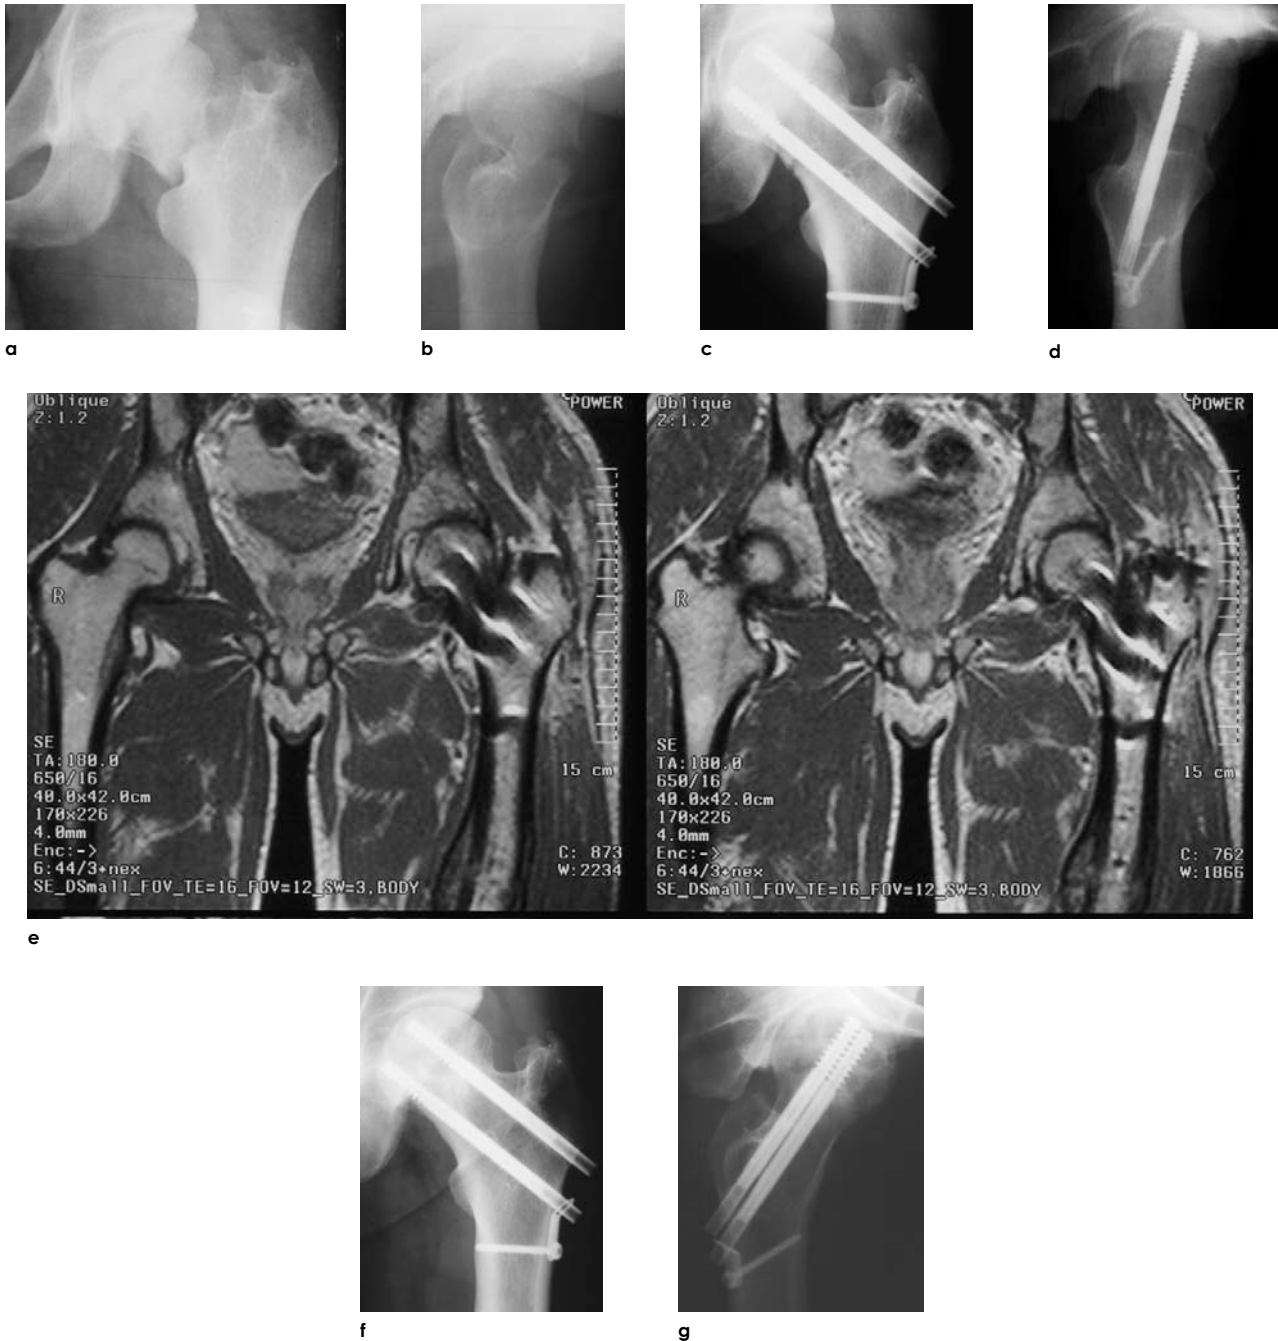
Early MRI after internal fixation of a neck fracture.
